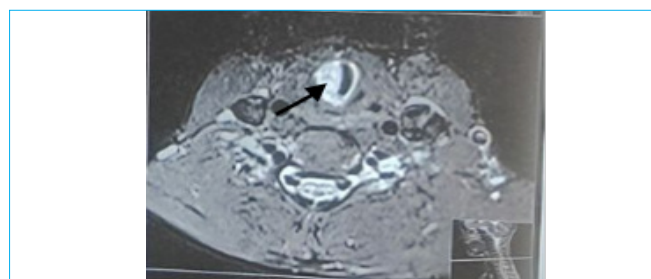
T2-weighted MRI showing subglottic stenosis and a lesion in the right lateral subglottic region (arrow)
